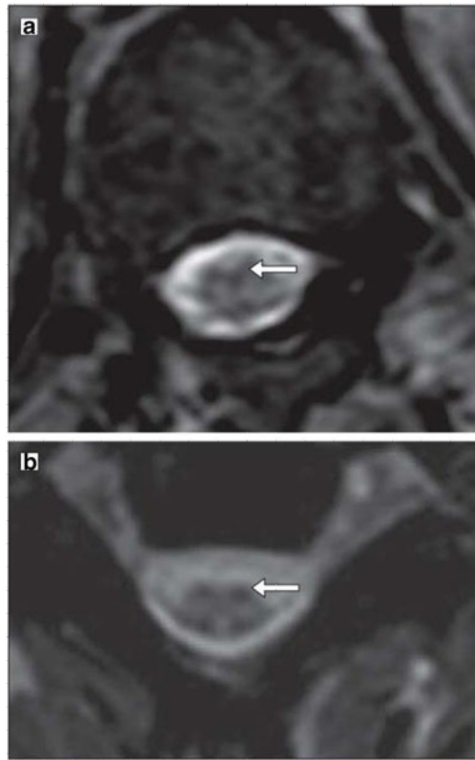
MRI after injection of Feridex®-labeled mesenchymal stem cells. a An axial T2-weighted gradient echo scan through the inferior thoracic cord shows a hypointense pial signal coating the cord similar to that of superficial siderosis, characteristic of Feridex®-labeled cells. b Axial T2-weighted gradient echo scan through the cervical cord shows hypointensity of the dorsal roots and their entry zone and a similar hypointensity of the ventral root entry zones, suggesting the presence of Feridex®-labeled cells. (Reproduced from Ref. 52, with permission)
